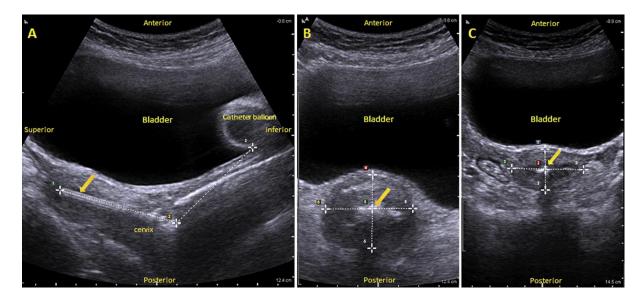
Longitudinal and transverse ultrasound image of uterus and cervix
